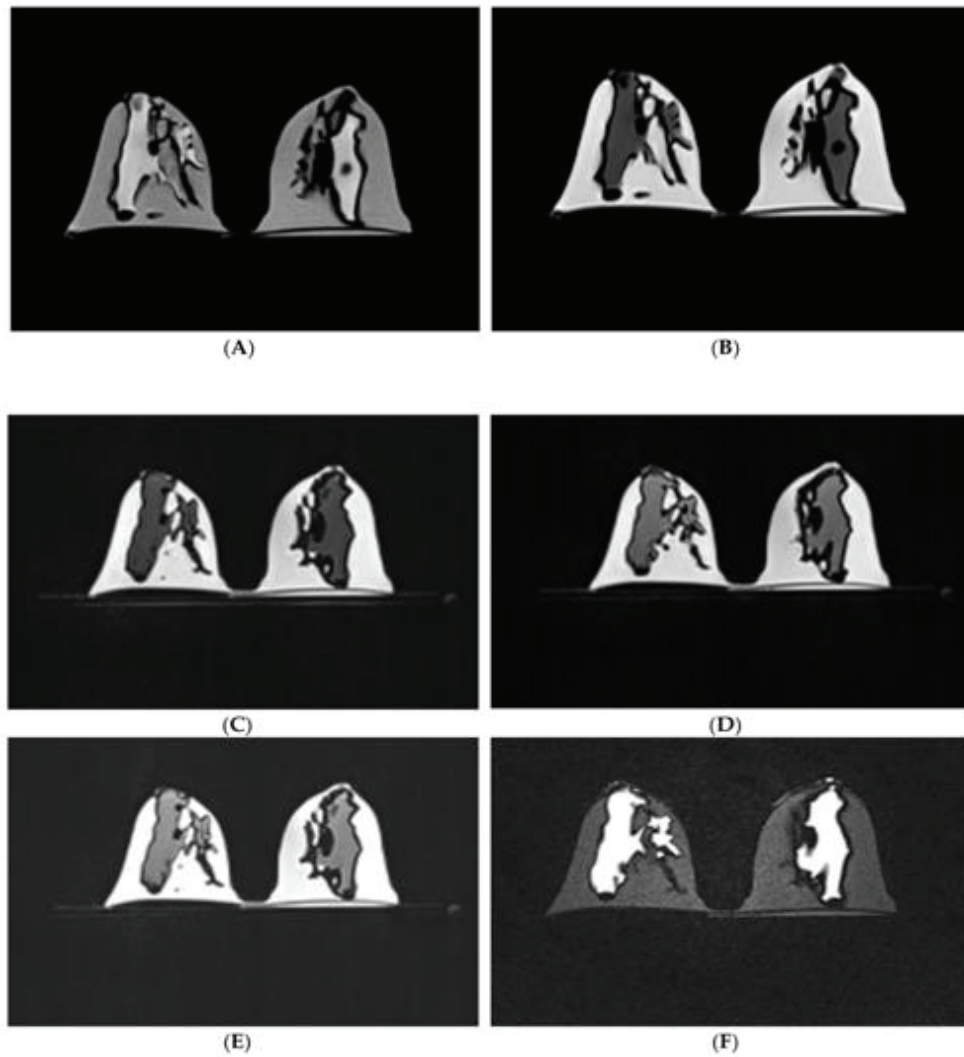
Central axial slice of a personalized 3D-printed breast model for the different MR imaging pulse sequences. (A) Non-fat-suppressed TSE (T2W); (B) Non-fat-suppressed TSE (T1W); (C) Non-fat-suppressed TSE SPACE (T1W); (D) Fat-suppressed TSE SPACE (T1W); (E) Fat-suppressed TSE SPACE SPAIR (T1W); (F) Fat-suppressed IR/PFP TIRM (T2W). For pulse sequences, refer to Table 4.1.
